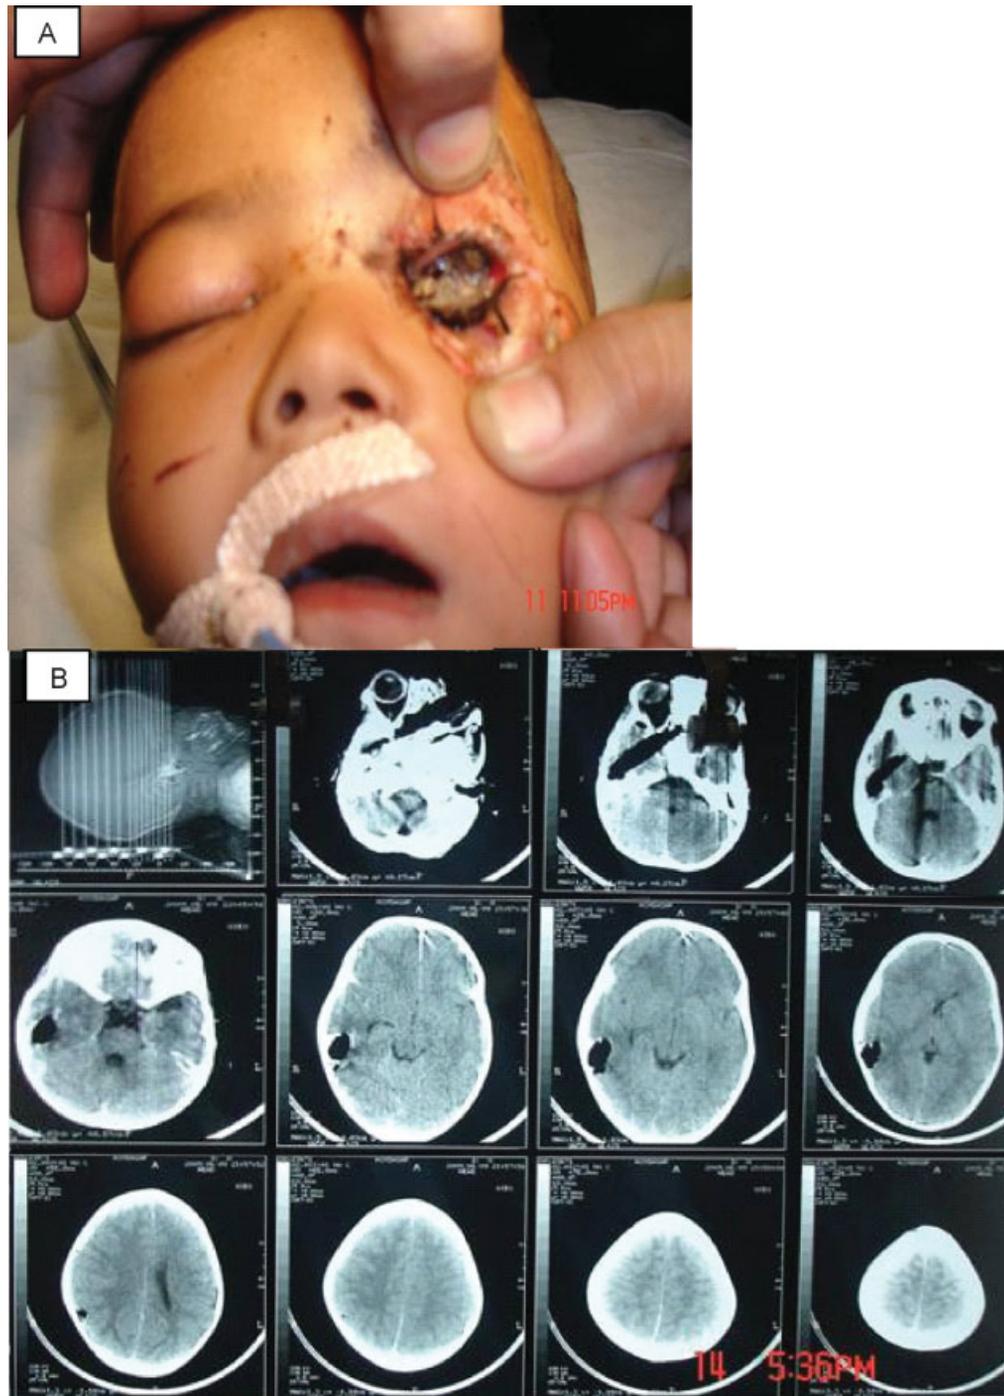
A 6-year-old boy with accidental injury by wooden stick. (A) The patient's photograph with injury through the left eye. (B) Noncontrast CT of the head showing foreign body crossing the midline and going to the right temporal lobe.
